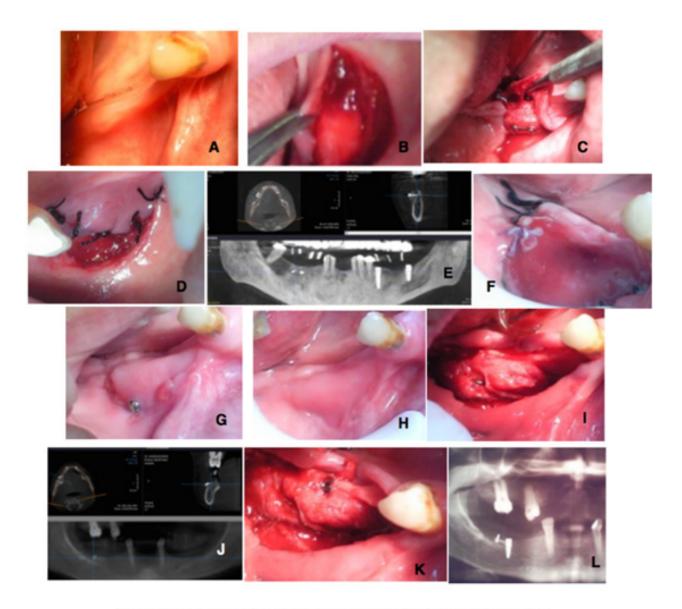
Ridge augmentation using Kazanjian vestibuloplasty.flap design: Fig A: Showing thin ridge. Fig.B:Showing Kazanjian vestibuloplasty. Fig.C:Showing Nanobone block fixation. Fig.D: Suturing of Kazanjian vestibuloplasty.. Fig.E: Showing CBCT after ridge augmentation. Fig.F: Showing healing one week after surgery. Fig.G:Showing one month after surgery. Fig.H: Showing six months after surgery. Fig.I: Showing new formed bone. Fig.J: Showing CBCT after Nanobone block augmentation. Fig.K:Showing new formed bone and implant placement. Fig.L: Showing CBCT six months after Nanobone block augmentation and implant placement.
